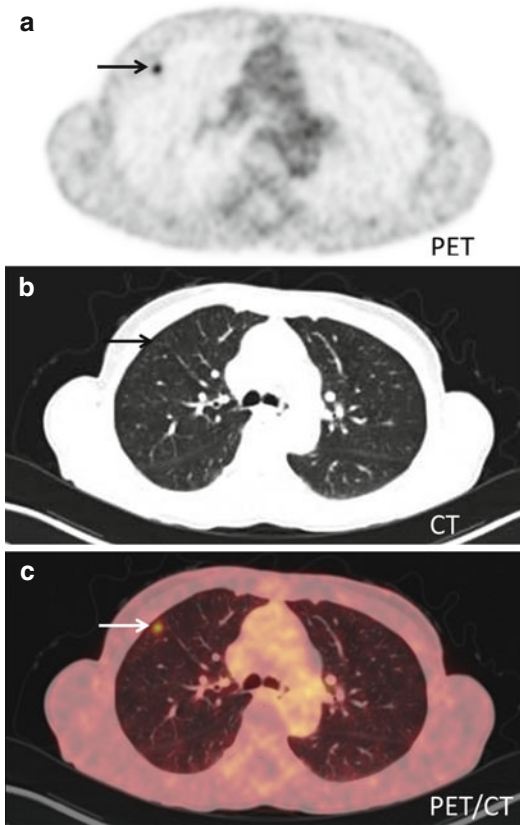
Transaxial PET-CT of a FDG-embolus: (a) FDG-PET shows a focal accumulation of isotope (*arrow*) in the anterior part of the right lung. (b) CT shows high-resolution anatomical images of the lung parenchyma. (c) Fused PET-CT shows that there is no anatomical correlate to the isotope accumulation – this was therefore interpreted as being a FDG-embolus. FDG-embolus is an aggregation of FDG which follows the bloodstream after the injection to the lungs where it is trapped in the capillary bed
